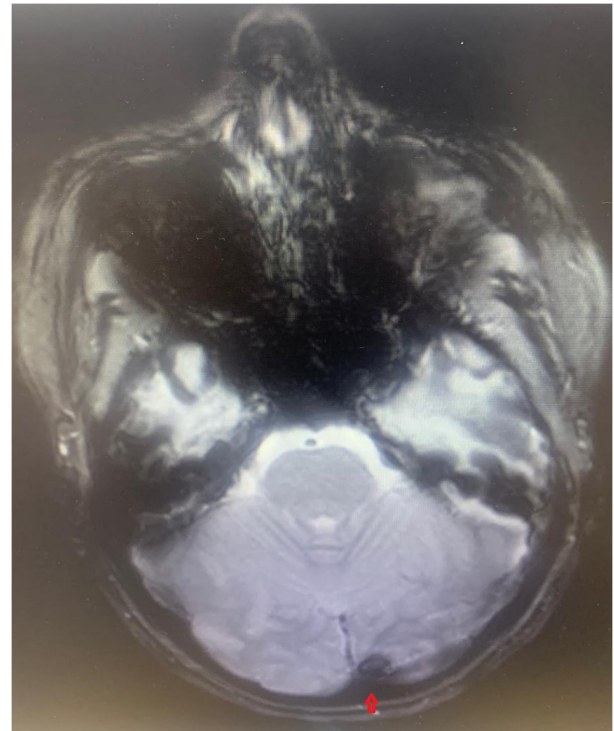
MRI T2-weighted axial section at the level of the pons. The arrow shows normal flow void of the terminal superior sagittal sinus and transverse sinuses. Image was obtained in November 2023.
